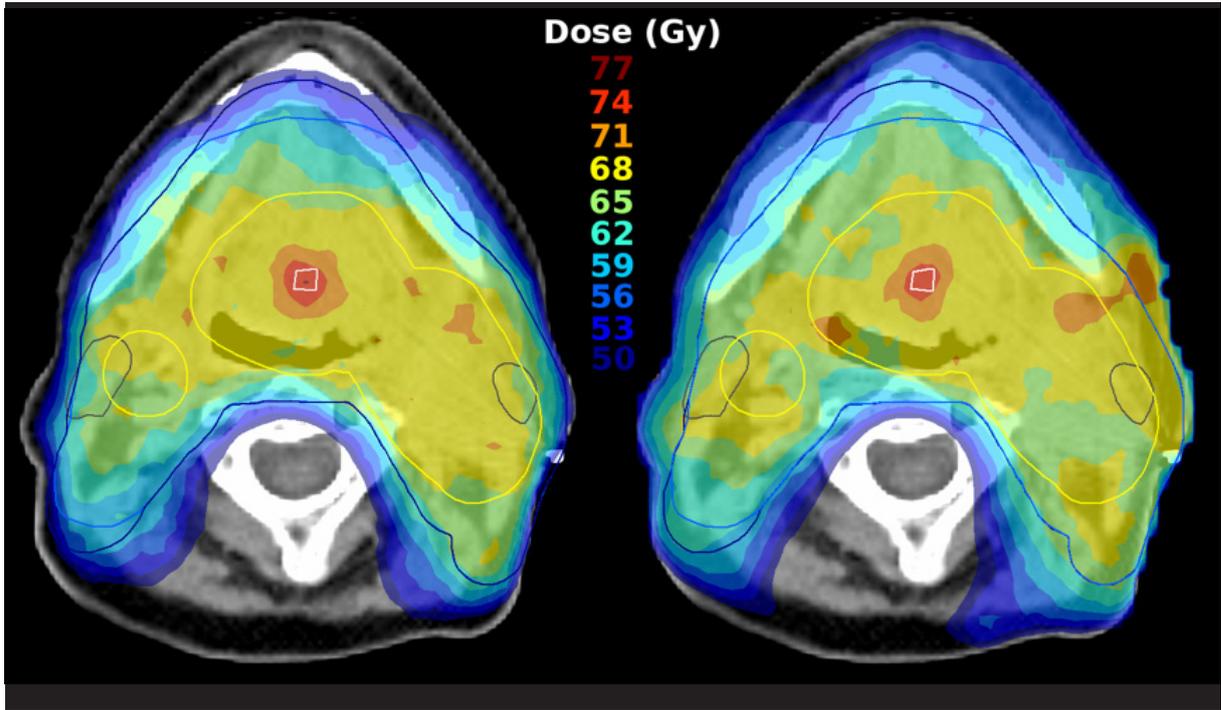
Exemplary dose distributions including local DE for a standard linac (left) and the MRI-linac (right). Contours of escalated volume,  $PTV_{70}$ ,  $PTV_{60}$ ,  $PTV_{54}$  and parotid glands are shown.
